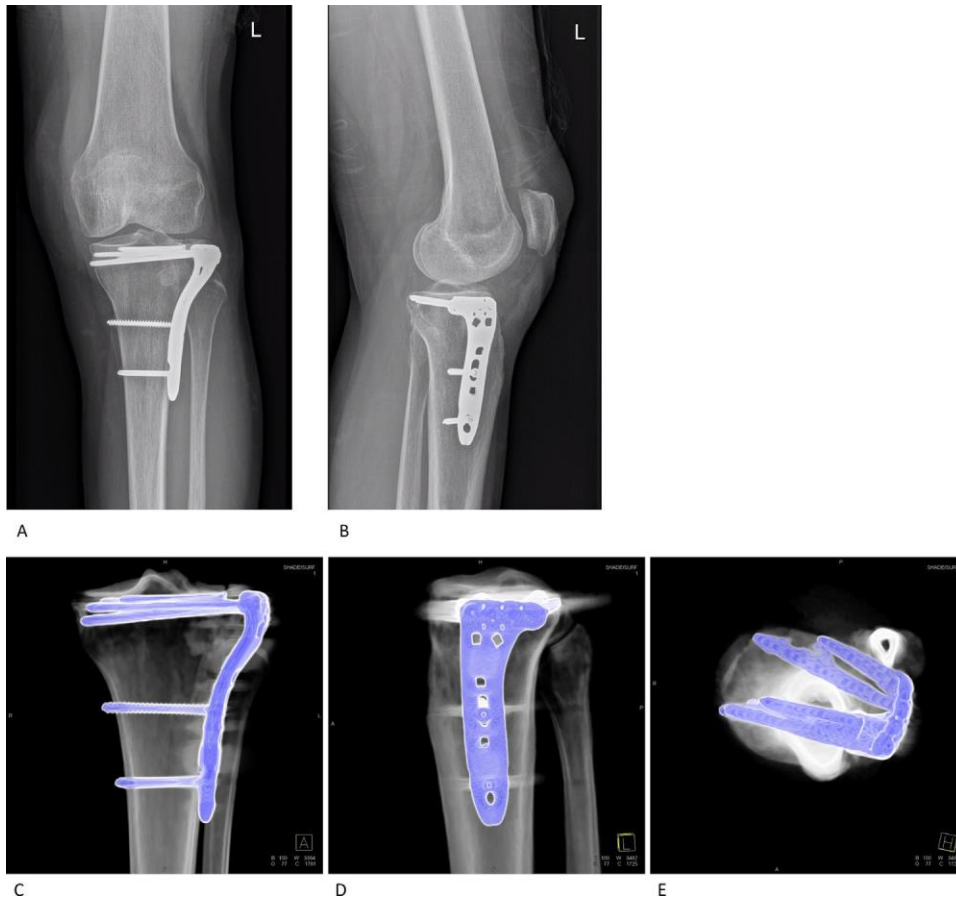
Postoperative coronal (A) and sagittal (B) radiographs, as well as VRT (volume rendering technic) CT with MAR (metal artefact reduction) coronal (C), sagittal (D) and axial (E) images show the free subchondral screws and the diverging VA-LCP locking (rafting) screw that provide articular support.
